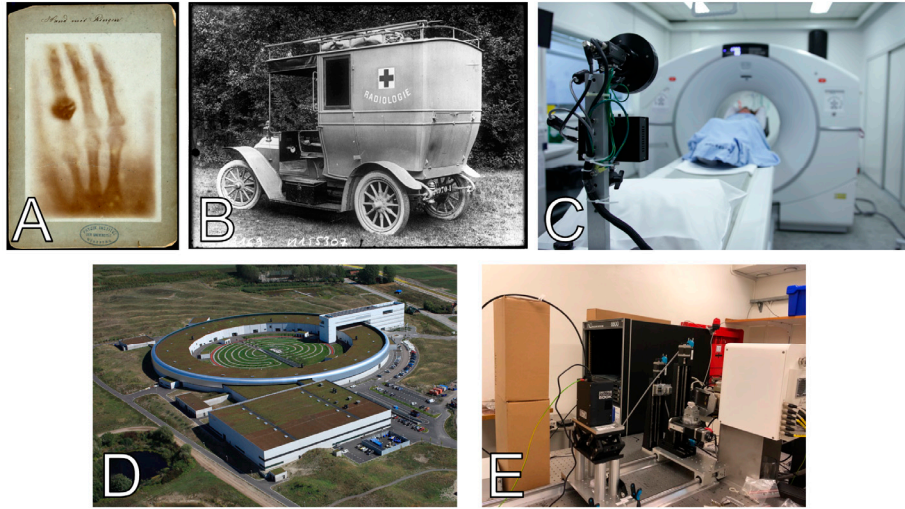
Examples of evolution of x-ray imaging.
